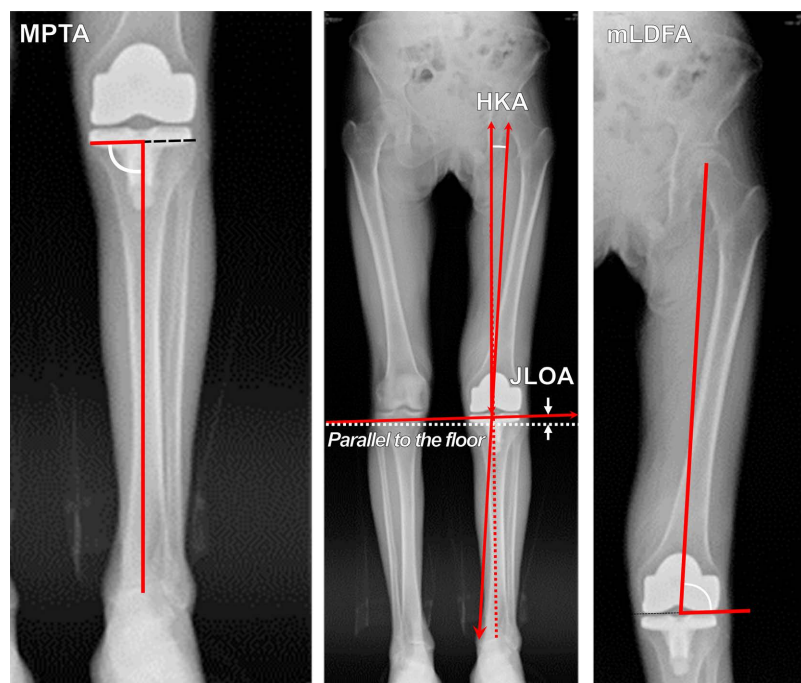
Radiographic data of Coronal Alignment. Measurements of coronal alignment from standing long leg radiographs. MPTA, medial proximal tibial angle; JLOA, joint line orientation angle; HKA, hip knee ankle angle; mLDFA, mechanical lateral distal femoral angle.
